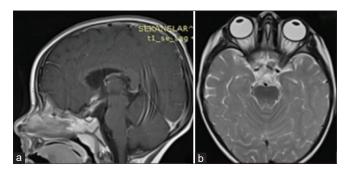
One-year follow-up magnetic resonance image: (a) T1-weighted image (sagittal section), affirm successful tumorectomy and decompression of optic chiasm with normal ventricular volume. (b) T2-weighted image (axial section), confirm successful tumorectomy and decompression of optic chiasm with no dilatation of the ventricles.
